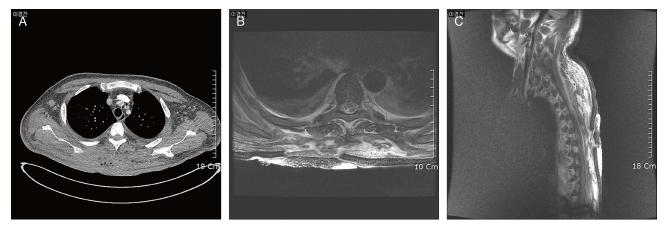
RADIOGRAPHIC EVALUATION WITH CONTRAST-ENHANCED COMPUTED TOMOGRAPHY AND MAGNETIC RESONANCE IMAGING
